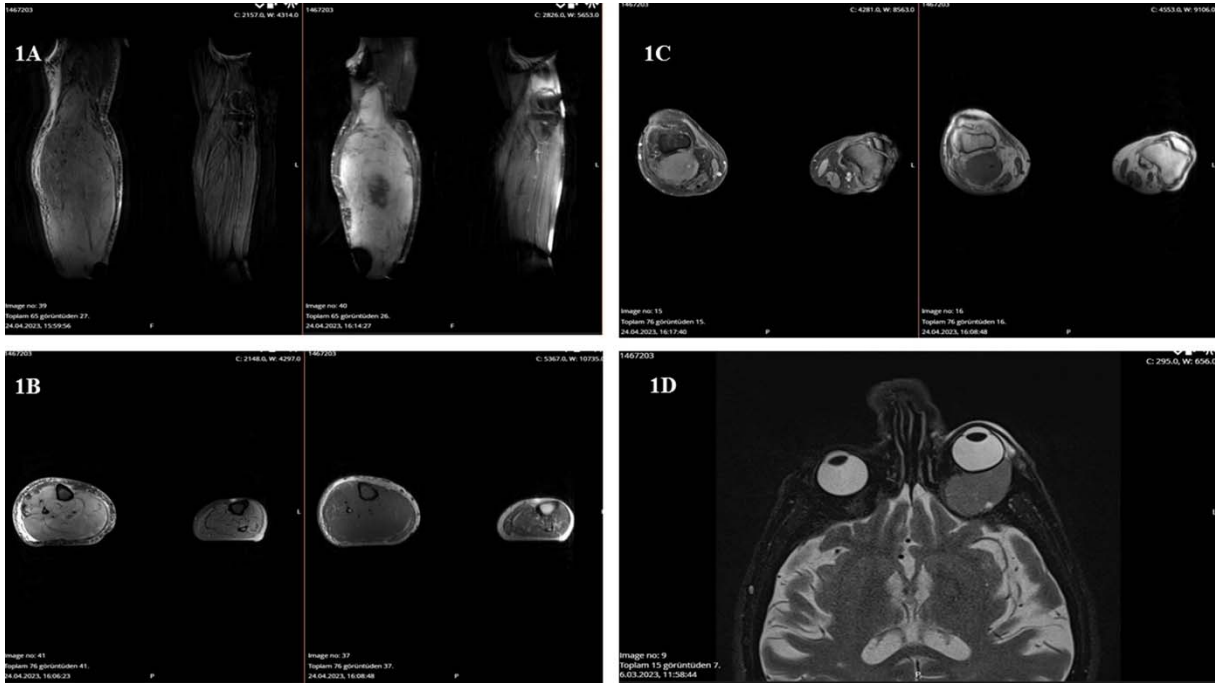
Magnetic resonance images of multiple myeloma involvement of the right lower extremity and left retroorbital region of the patient with atypical presentation. Soft tissue lesions that cannot be clearly separated from the adjacent muscle planes along the femoral region and cruris, and muscle involvement in the entire right cruris are seen (figure A-C). Left retroorbital 22x32x22mm mass in orbital MRI (D).
